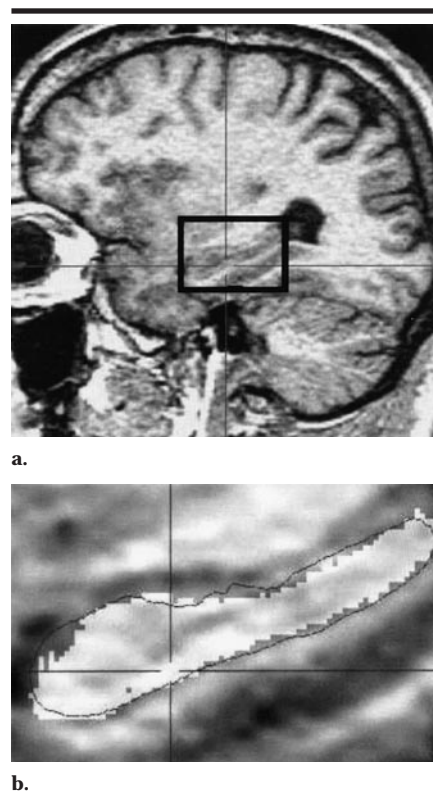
Patient 2. (a) Sagittal fast spoiled gradient-recalled MR image (14/3, flip angle of 30°) through the left hippocampus. The region of interest is outlined in black. (b) The region of interest outlined in a is superimposed with manual (white shading) and deformation-based (gray outline) segmentations. (Original magnification, $\times 4$.)
